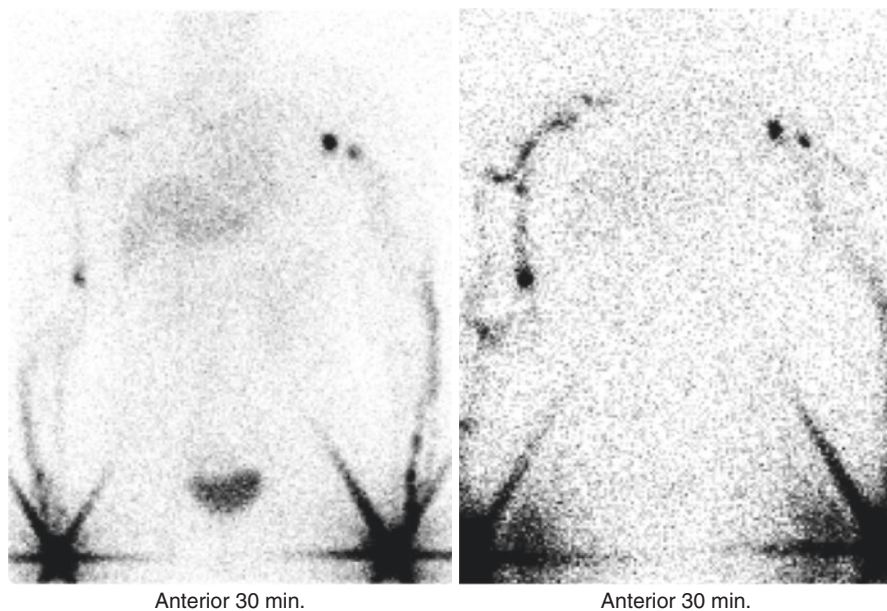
Lymphoscintigraphy of the patient showed in Fig. 16.3. Before VLNT (left) and 6 months post-VLNT (right)
